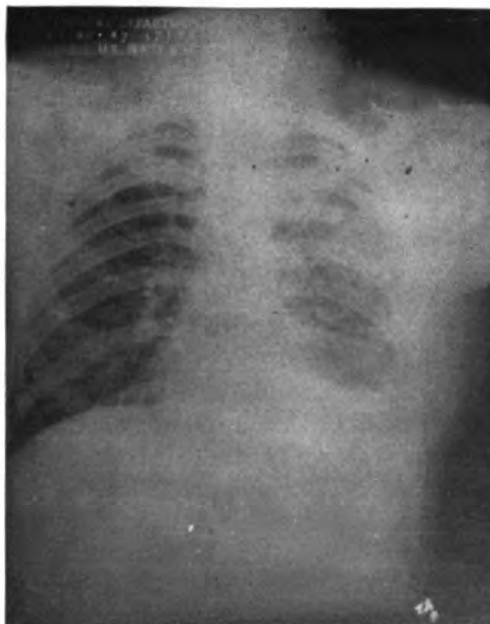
Case 2. Postoperative x-ray showing complete reexpansion of the left lung following decortication. A small amount of fluid is present which absorbed without aspiration.
